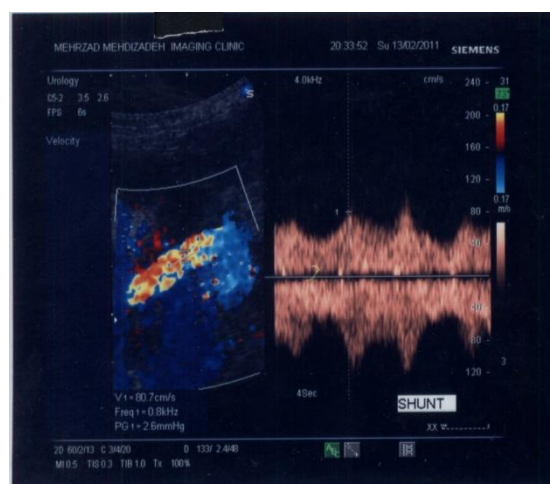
Color doppler of a portal venous thrombus in a case with 2.5 years old.
